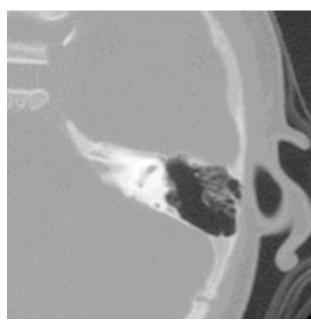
Axial CT scan demonstrating a normal right internal auditory canal in Subject 2 (image on the left) and a narrow left internal auditory canal (image on the right).
